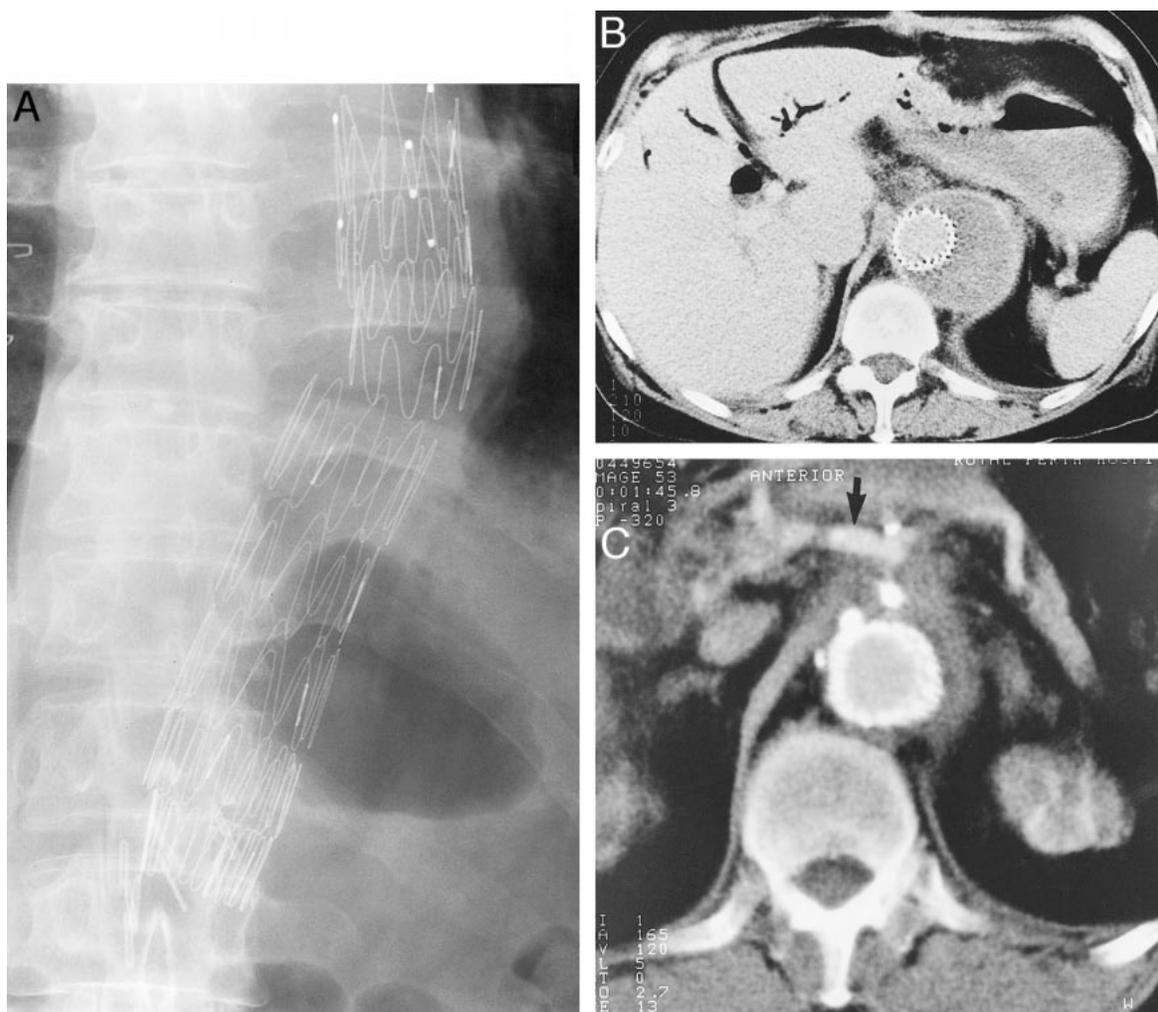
♦ (A) The stent-graft is easily visualized on noncontrast radiography in the female patient before discharge. The Ligaclips seen at the lower end of the stent mark the site of the Dacron ring sutured circumferentially to the aorta and stent-graft. The computed tomography scans show adequate exclusion of the aneurysm in the female patient (B) before discharge and in the male patient at 1 month (C). In the latter scan, note the satisfactory flow through the hepatic artery (arrow).
